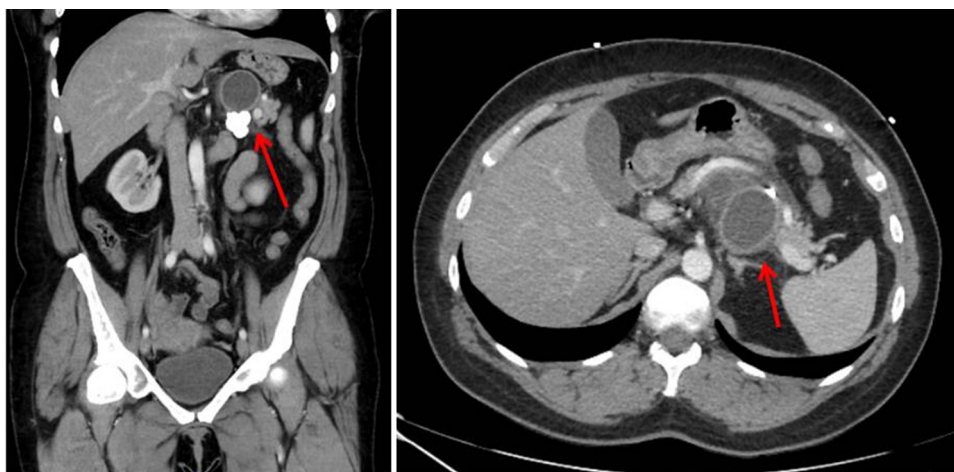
CT demonstrates a 7.3 × 6.7 cm cystic lesion (red arrow).
